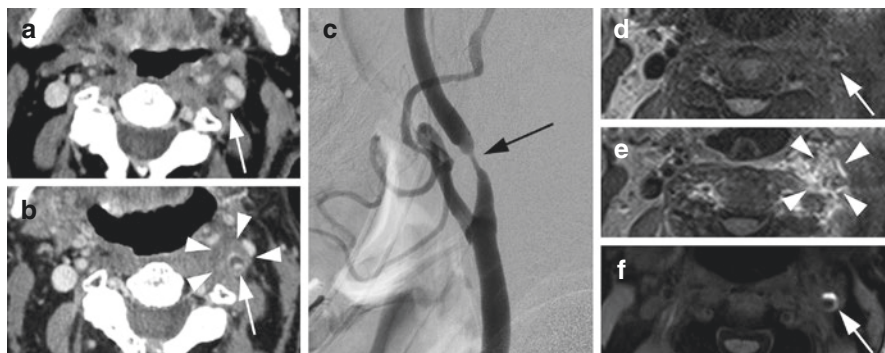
85-year-old male with prior radiation therapy for squamous cell carcinoma with CTA scan 1 year prior (a) and on presentation with acute left neck pain localizing to the left carotid artery (b). ICA stenosis progressed between the two scans (arrows), and there was active inflammation on CT with perivascular stranding and indistinct fat planes (arrowheads). DSA was performed (c) confirming severe left proximal ICA stenosis (arrow). Vessel wall MRI pre (d) and post (e) contrast T1-weighted flow-suppressed images demonstrated indistinct fat planes around the left ICA (d, arrow) and avid periaxial enhancement (e, arrowheads) with contrast leakage into the surrounding soft tissues. MPRAGE (f) also revealed T1-hyperintense intraplaque hemorrhage (arrow)
